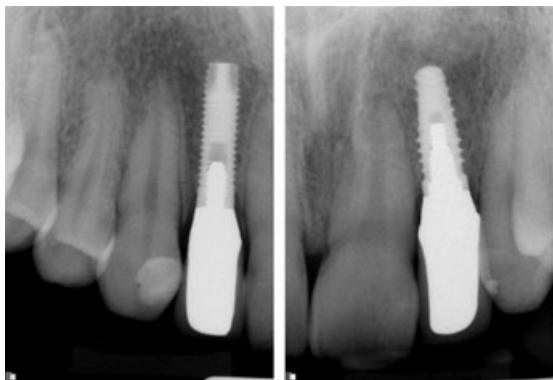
Periapical radiographs of the patient in Figure 1 with metal ceramic crowns in place, seated on custom abutments.
